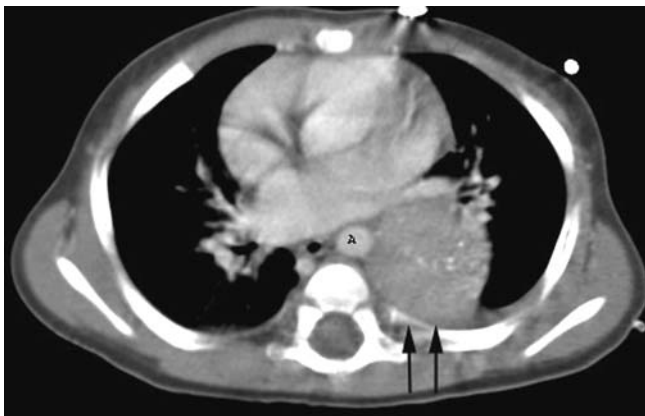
Contrast-enhanced CT of the chest demonstrates a large mass (*arrows*) in the left posterior mediastinum. This mass has low attenuation and does not appear to be enhancing when compared with the adjacent heart chambers and aorta (*A*). A few punctate calcifications were noted. This was pathologically proven to be a thoracic neuroblastoma
